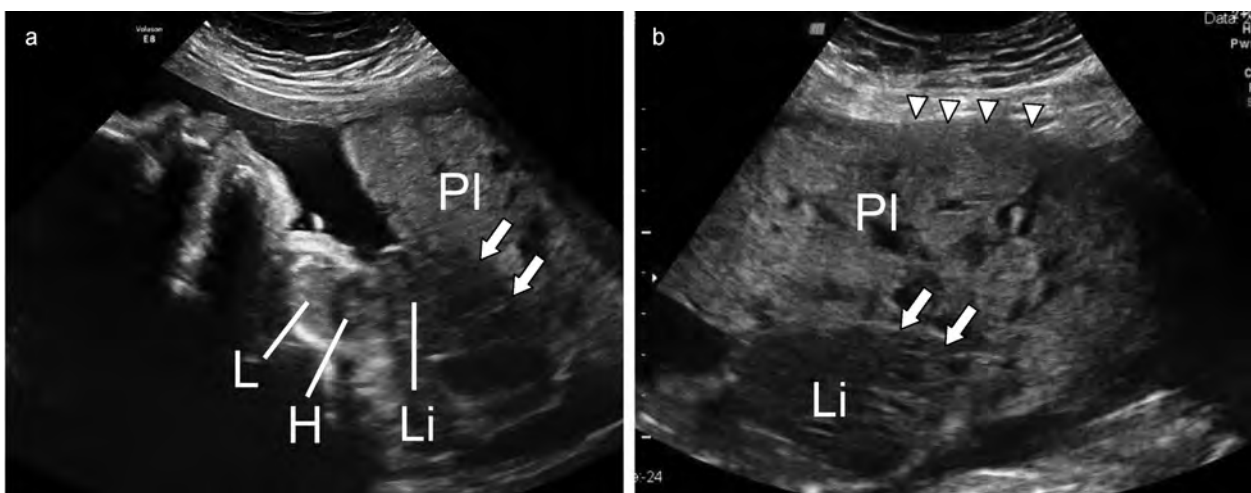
Ultrasound image at 32 weeks. (a) Fetus in longitudinal view showing extensive abdominal wall defect, heart moved to the caudal position, and liver in contact with the placenta (arrows). (b) Placenta in the segmental region showing several vascular voids and loss of the myometrial layer (arrowheads). One can also see the fetal liver near the placenta (arrows). Abbreviations: PL, placenta; L, Lung; H, heart; Li, liver.
